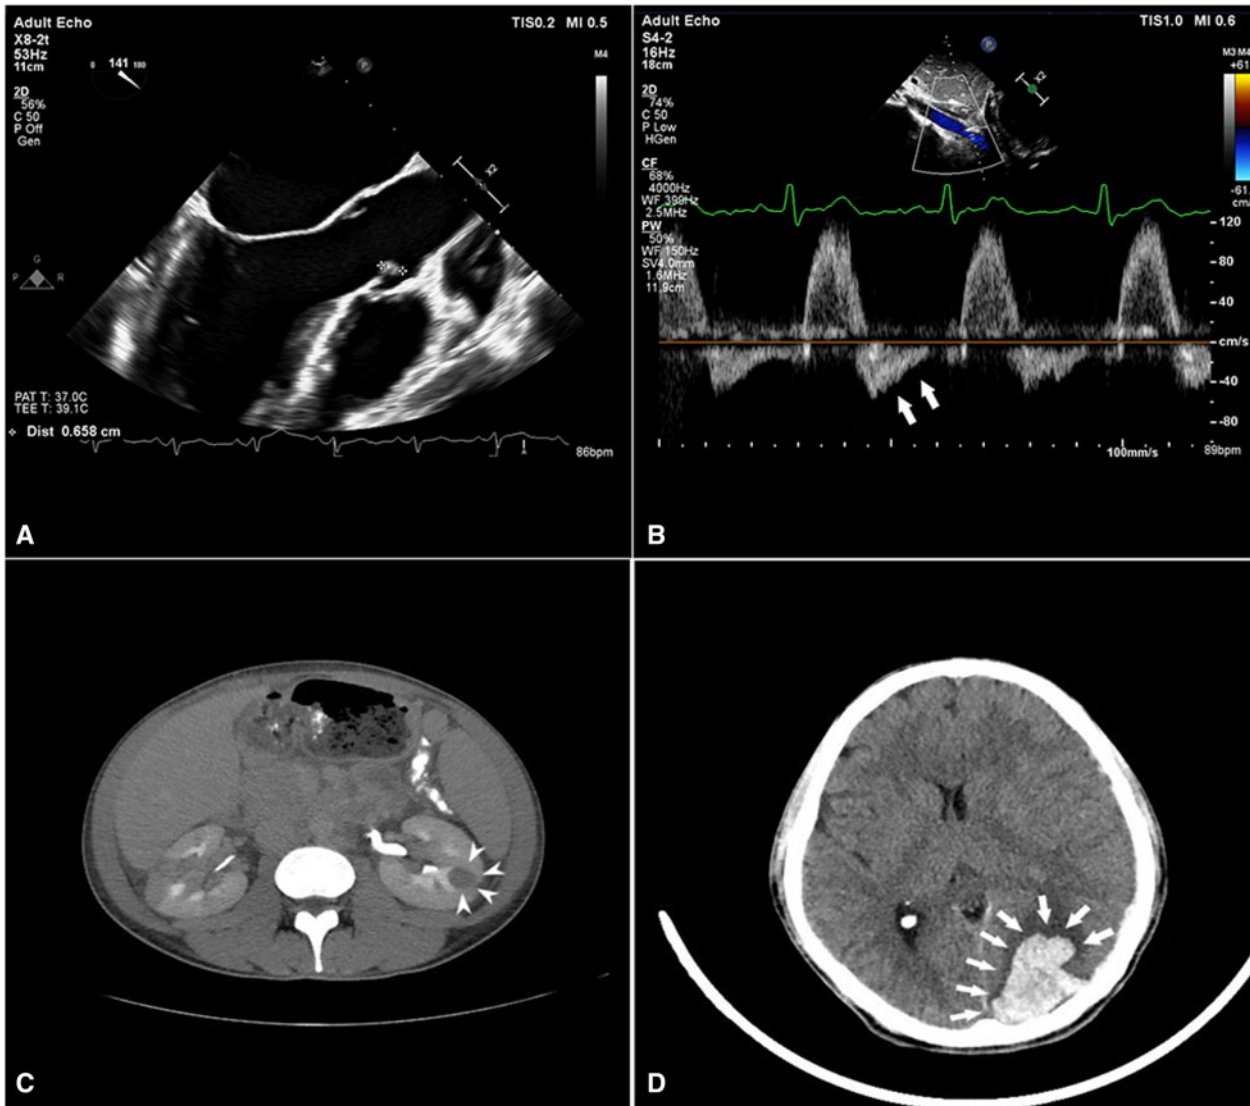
(A) Long-axis midesophageal transoesophageal echocardiography view demonstrating vegetations on the aortic valve; (B) holodiastolic flow reversal in the abdominal aorta (white arrows) indicating severe aortic regurgitation; (C) left kidney infarct on abdominal computed tomography (white arrowheads); and (D) intracerebral haemorrhage on head computed tomography (white arrows).
